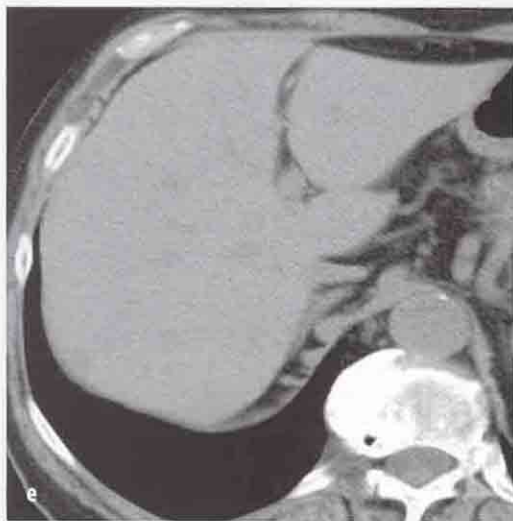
Metastasis.* Baseline US examination shows a subcapsular hypoechoic nodule (a). At contrast-enhanced US the lesion shows rim enhancement during the arterial phase (b) with hypoechoic appearance in the portal-venous and delayed phases (c, d). At multidetector CT, the metastatic nodule appears hypodense in the baseline scan (e) as well as in the arterial (f) and the delayed phases (g)
